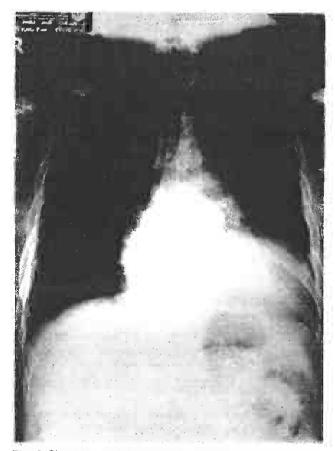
Chest Xray of Case 9 showing considerable cardiomegaly.
